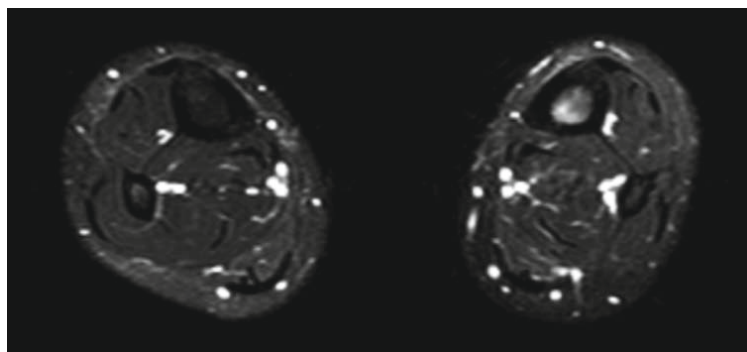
Axial T2-weighted image of the legs, showing bone marrow edema in the left leg of an athlete with MTSS.
